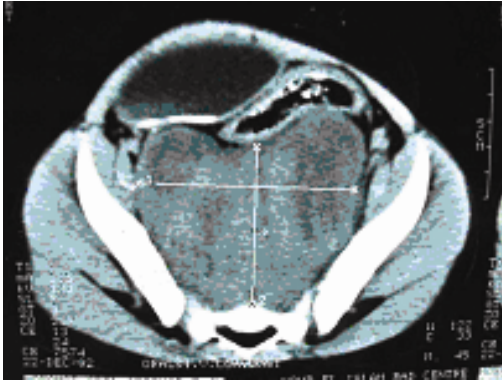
CT scanning shows a huge intrapelvic mass pushing the bladder and rectum anteriorly.
